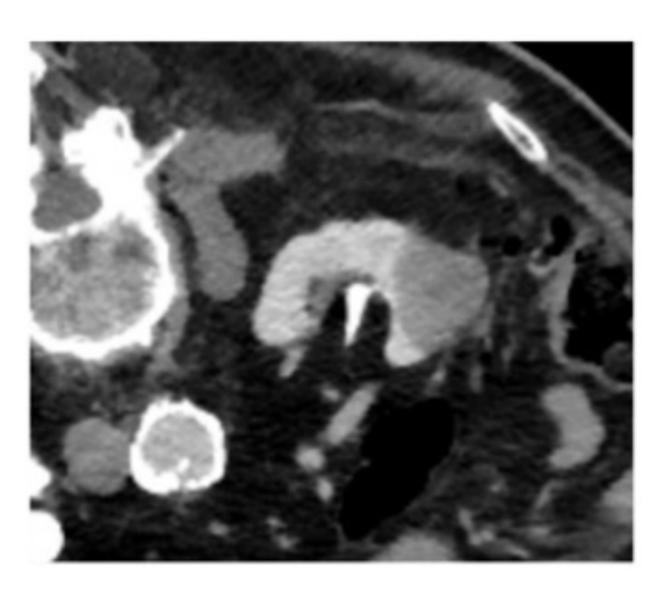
CT scan post cryoablation of the kidney lesion without damage to adjacent structures and successful retraction of the balloon.
